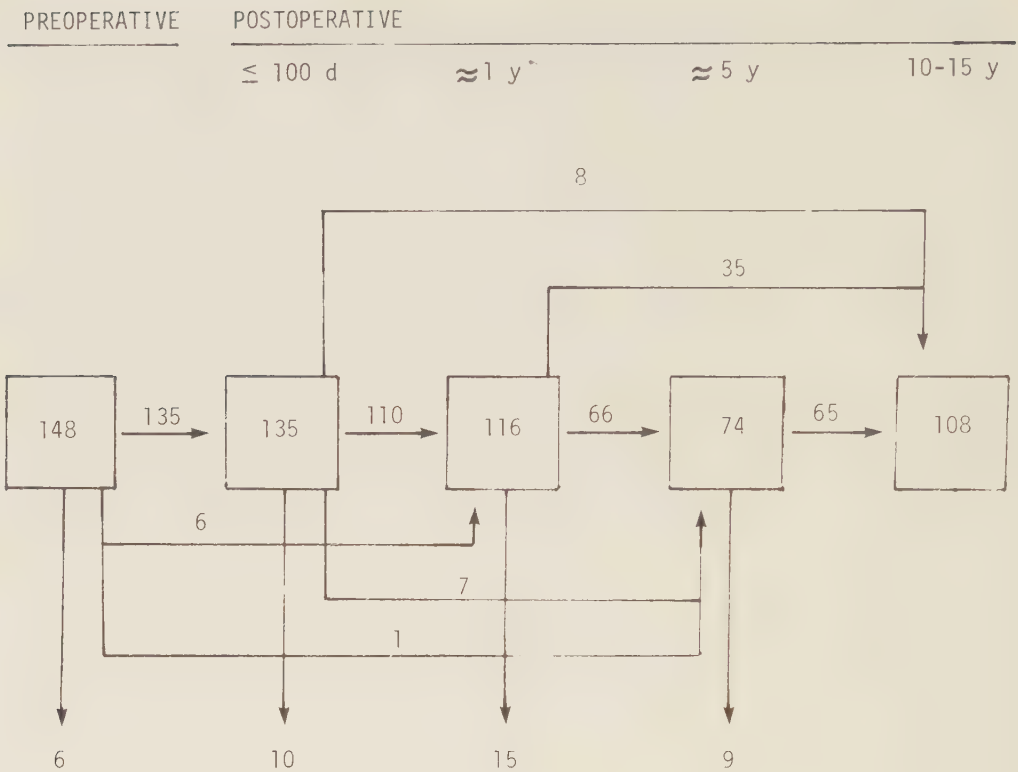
Echocardiographic examinations at different time intervals after surgery. Figures indicate number of patients examined. Arrows pointing downwards indicate patients who had no further echocardiographic examination.
